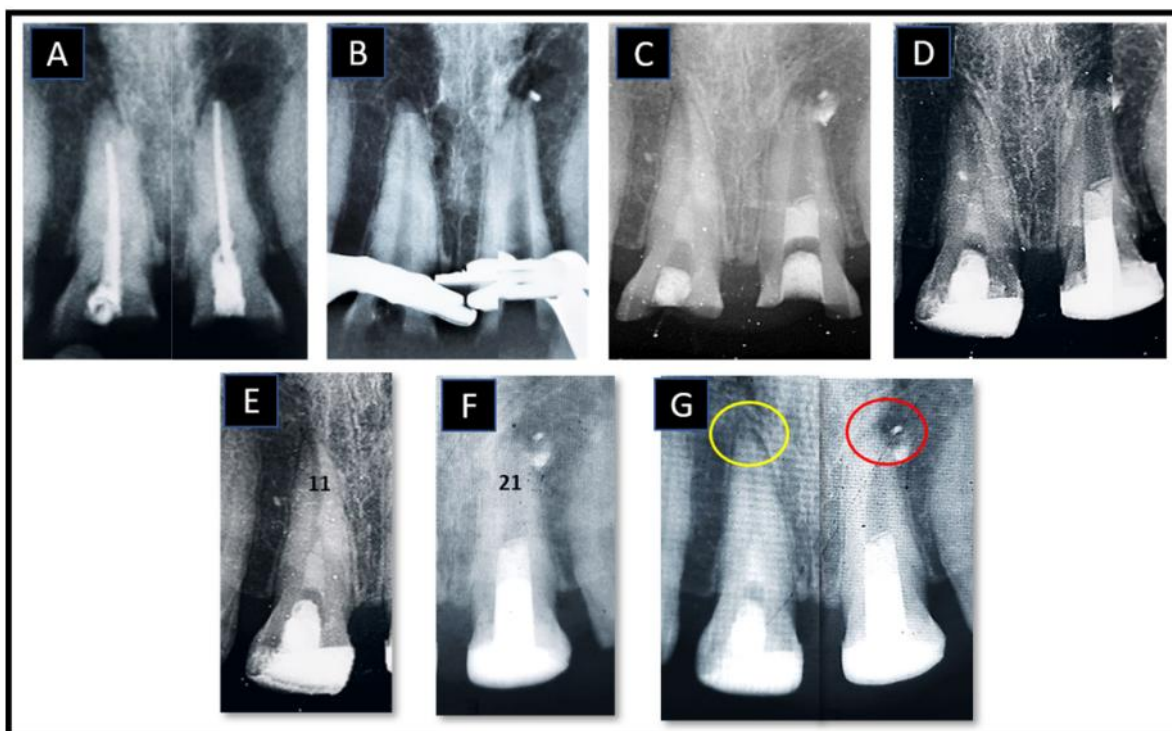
A. Poorly obturated 11 and 21 with periapical radiolucency. B. GP removed C. 3mm of MTA placed over PRF below CEJ. D. Immediate post-op. E&F. 9 months follow up G. 12 months follow up showing resolution of peri-apical radiolucency.
